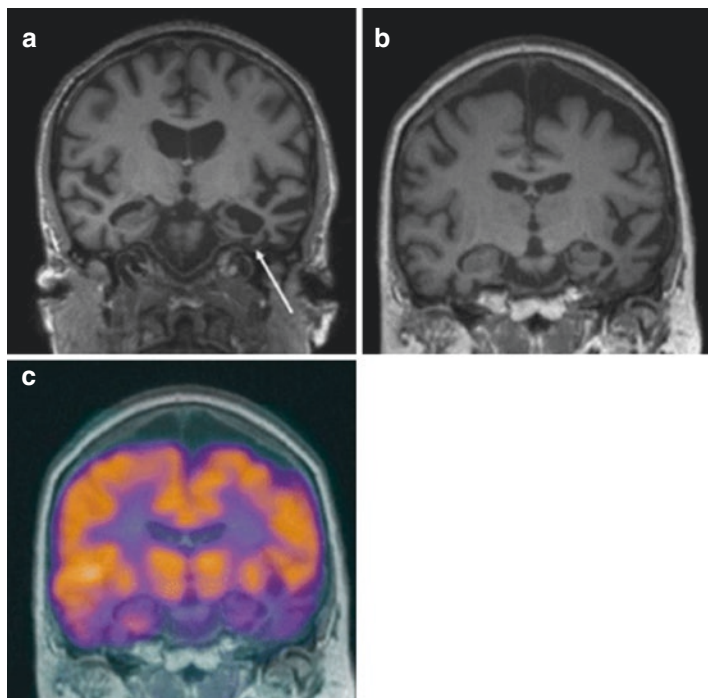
Coronal T1-weighted images (a and b) and fused FDG-PET/MRI image (c) in a patient with semantic variant PPA (semantic dementia). a and b: marked asymmetrical volume loss is found in the left temporal lobe affecting all temporal gyri and particularly the fusiform gyrus (arrow). c: the FDG-PET/MRI demonstrates glucose hypometabolism not only in the left but also in the right temporal lobe, which shows much less atrophy. PPA (primary progressive aphasia)
